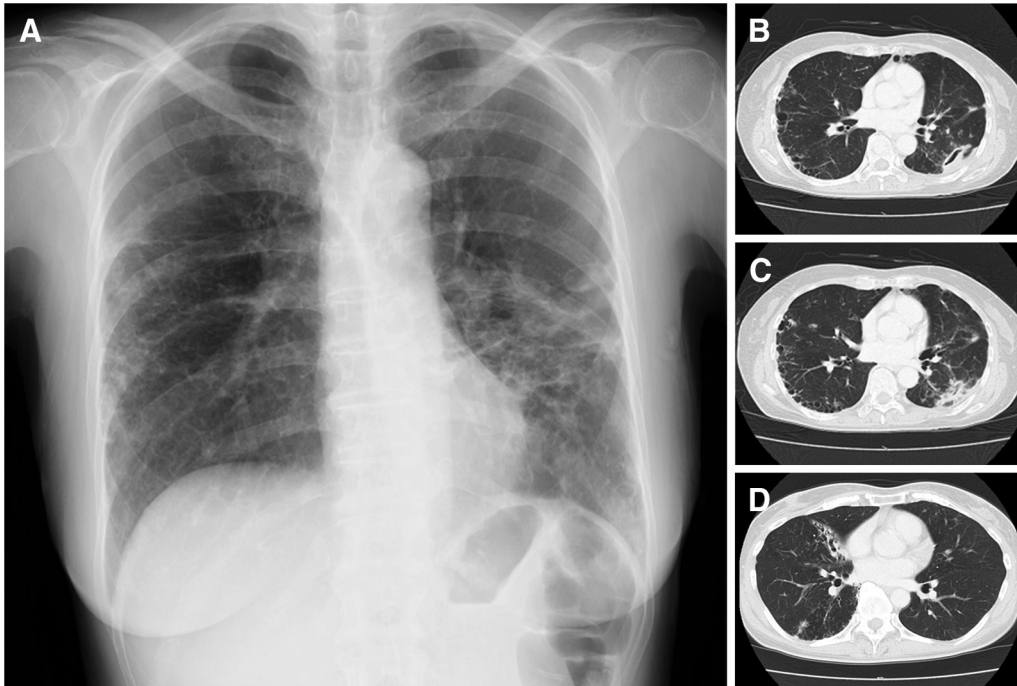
A typical chest X-ray of a patient with NTM-PD showing (A) infiltrative shadows in the lung field and a chest CT revealing (B) a cavity lesion, (C) a nodular lesion, and (D) bronchiectasis in the lung field. NTM-PD, nontuberculous mycobacterial pulmonary disease; CT, computed tomography
